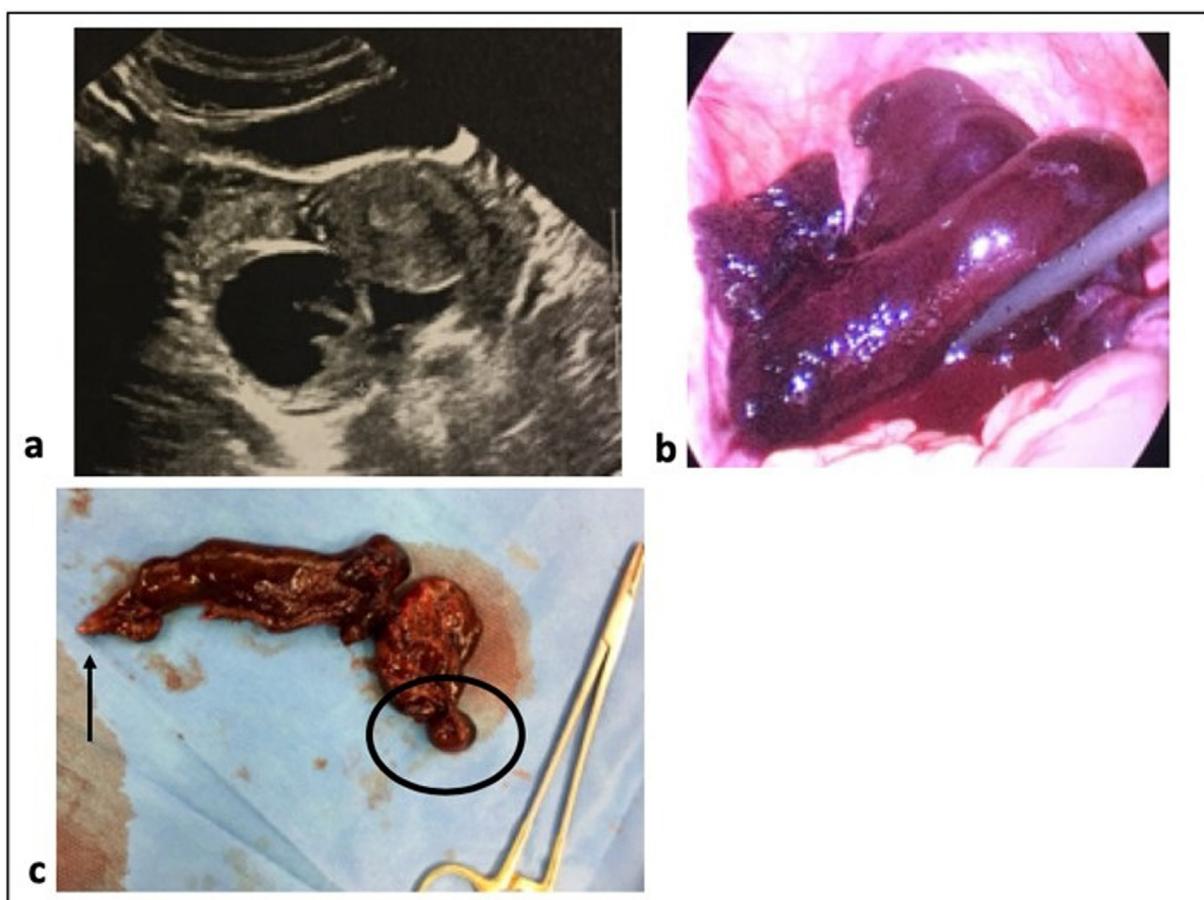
a. Suprapubic ultrasound view: hypoechoic image evocative of tubal origin with incomplete septations.
